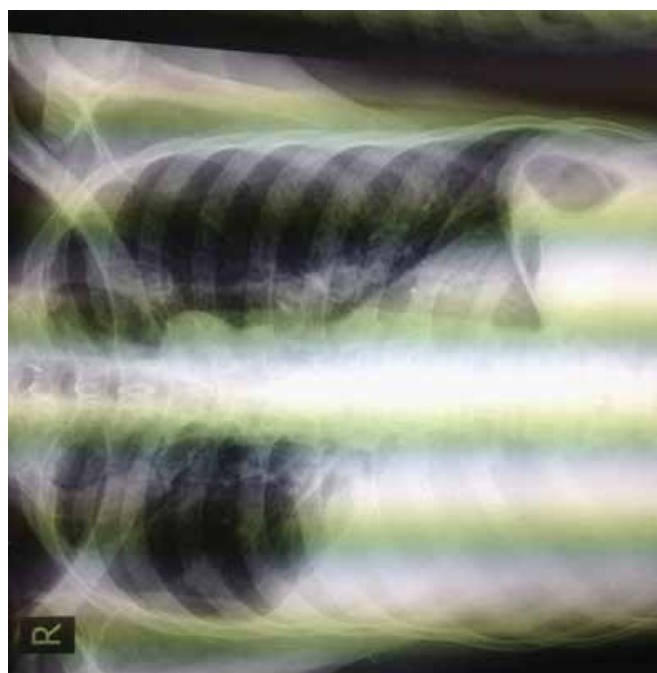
Chest radiograph showing pleura effusion.
